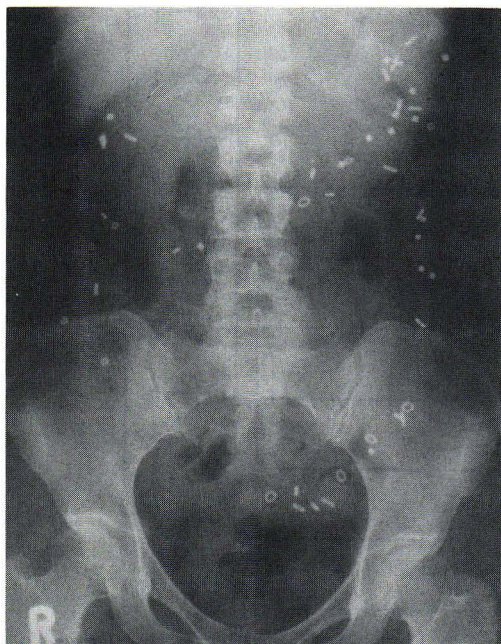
Plain radiograph of the abdomen showing the radiopaque markers.
